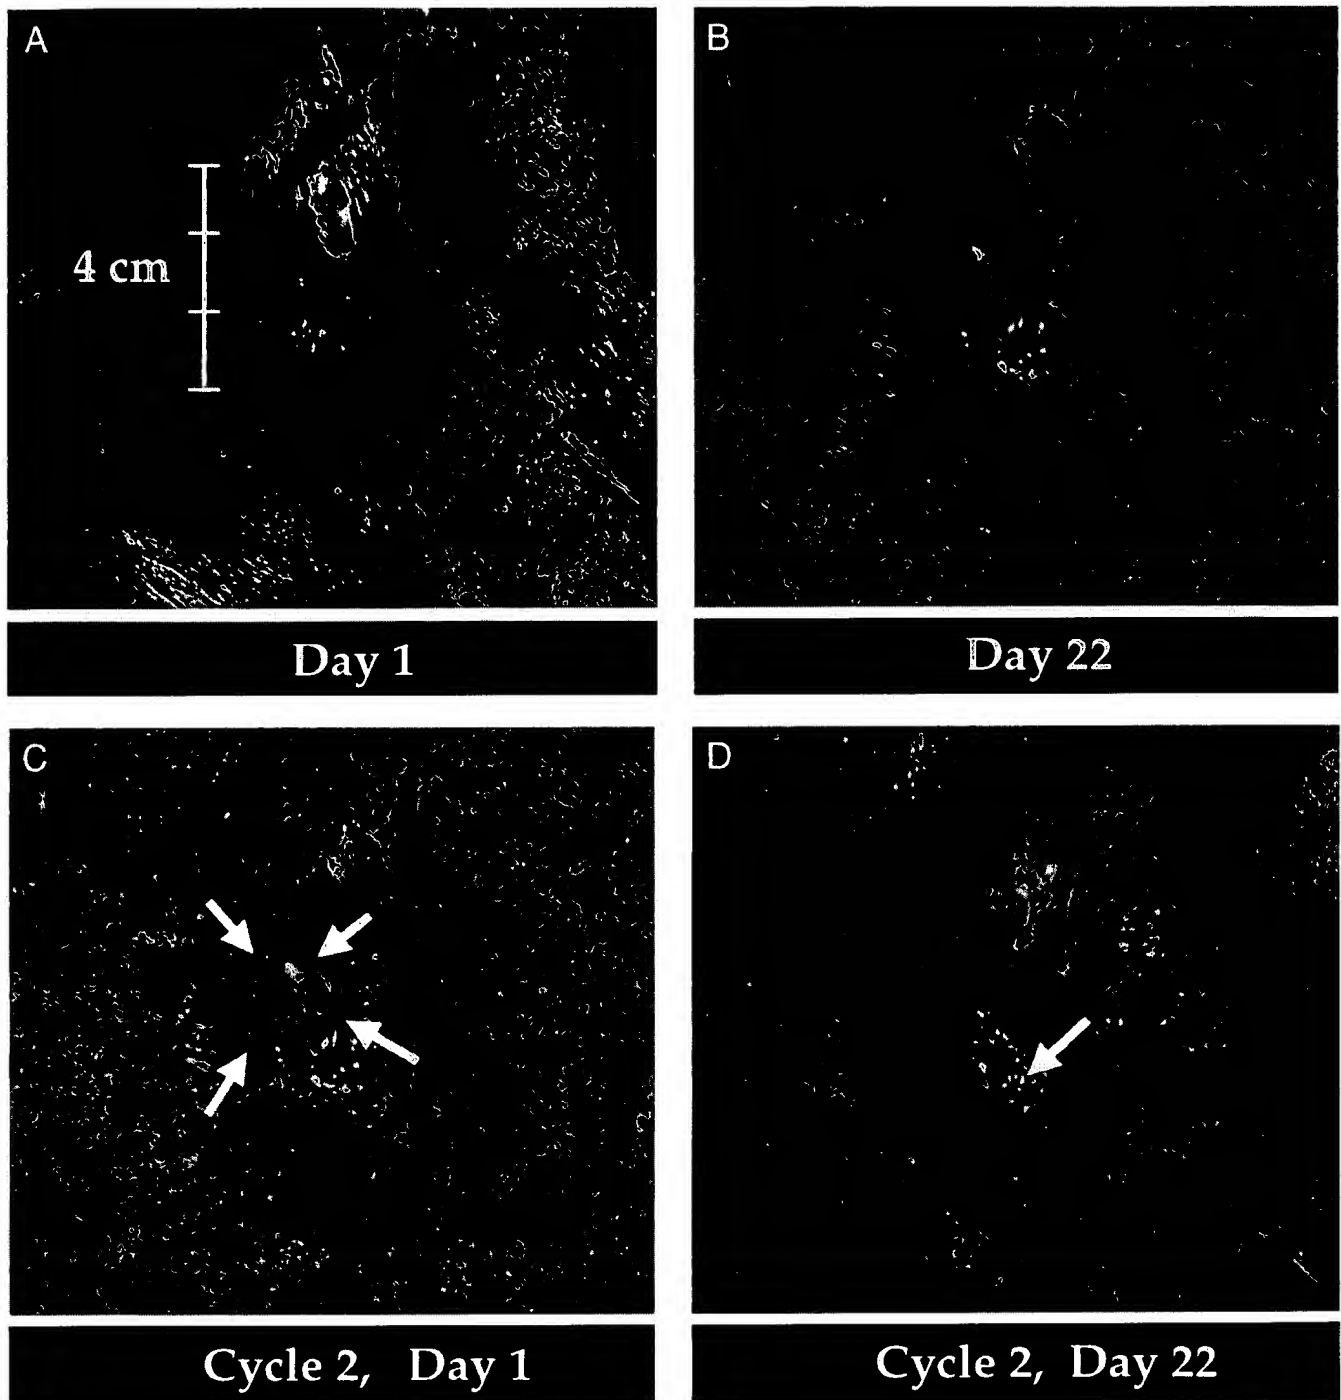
Evidence of selective tumor destruction after injection of ONYX-015 into both tumor tissue and normal tissue. This patient had a 4-cm left-neck recurrence after prior surgery, radiotherapy, and chemotherapy (A). The tumor was partially wrapped around the carotid artery and was, therefore, unresectable. ONYX-015 was injected into the tumor mass and surrounding normal tissues as demonstrated in Fig. 1. On day 22 after treatment initiation, a complete response was evident both clinically (B) and radiographically; no damage to the injected peritumoral normal tissue is evident. On days 22–26, a second 5-day course of ONYX-015 was injected entirely into the normal tissue adjacent to the tumor bed [arrows, injection locations (C, Cycle 2, Day 1; D, Cycle 2, Day 22)]. Despite direct injection of the entire dose of ONYX-015 into the normal tissue for 5 consecutive days, the normal tissue was clinically unaffected on day 44 (D). Arrow, granulation tissue healing into the ulcerated area.
